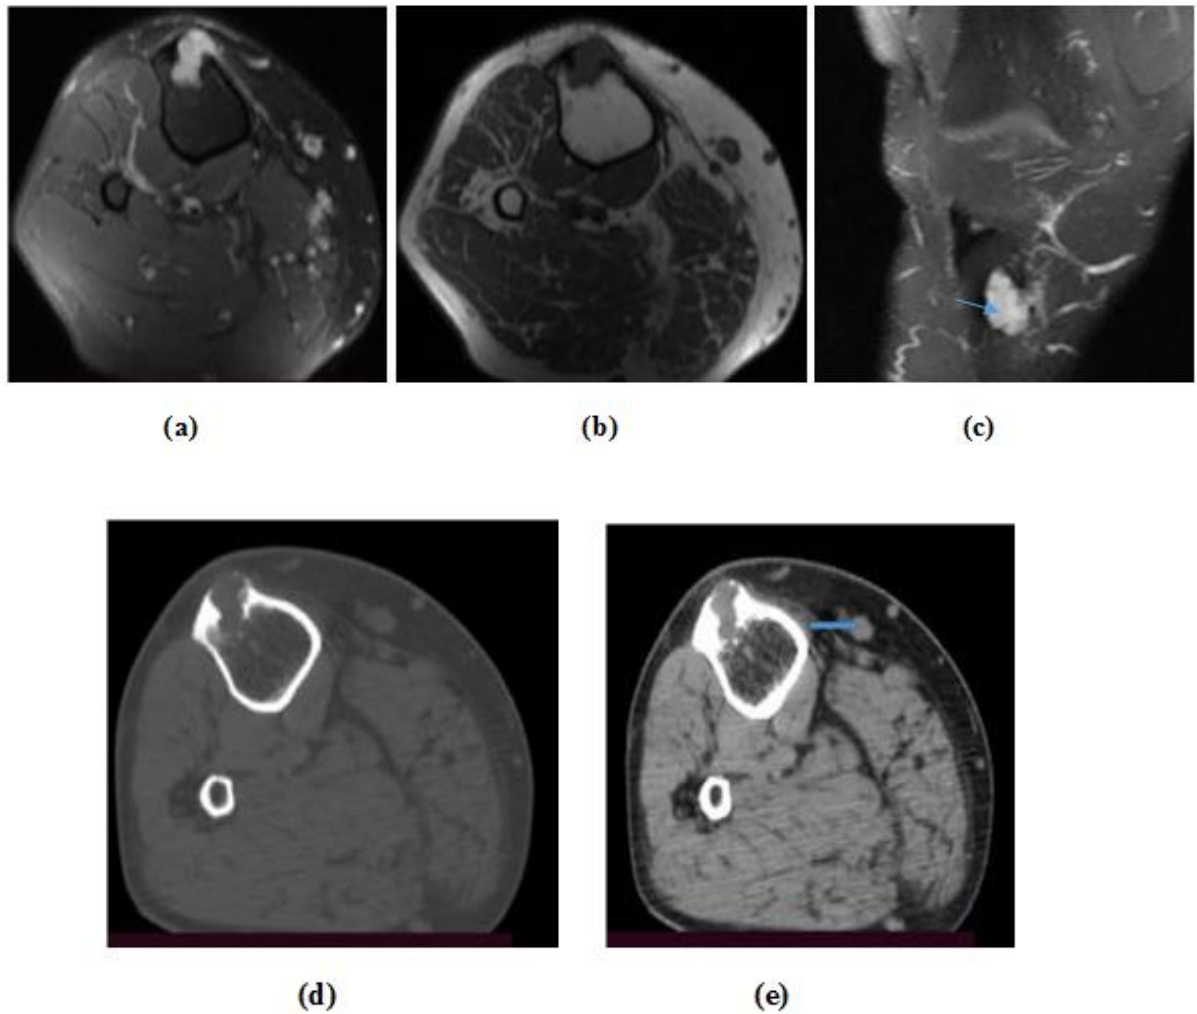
A-E, a &b) axial T1WI pre and post contrast, c) coronal PD, d&e) CT axial bone window& soft tissue window images show rather defined oblong shaped exophytic osseous lesion seen at the anterior border of the upper third of the tibia displayed mixed signal intensity being iso to low signal intensity at T1WI with multiple internal signal voids and high signal intensities at T2WI and STIR corresponding to the chondroid matrix (thin arrow) , with moderate post contrast enhancement, the lesion is seen indenting the cortex with possible disruption (thick arrow).
